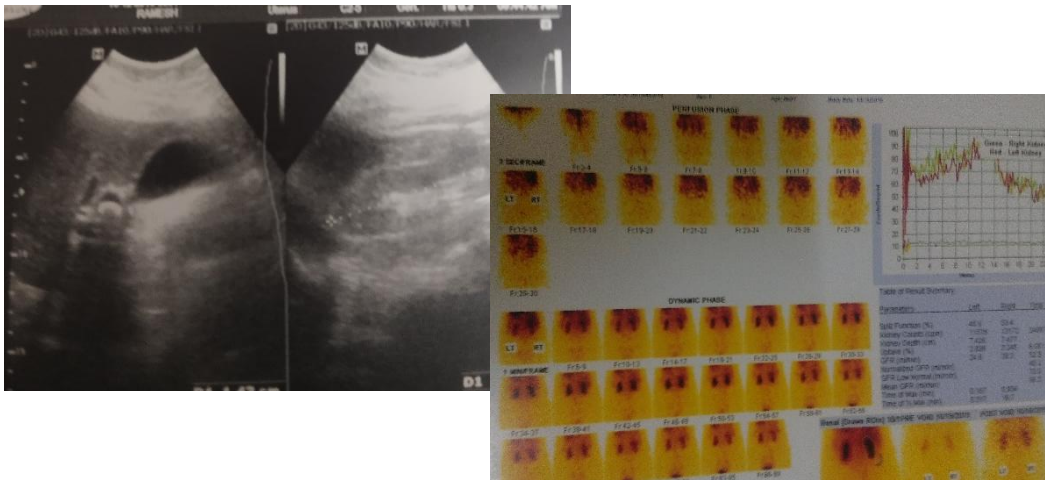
(a) preoperative ultrasound showing thick-walled Gall bladder with stone, (b) DTPA scan showing poor left renal functions
